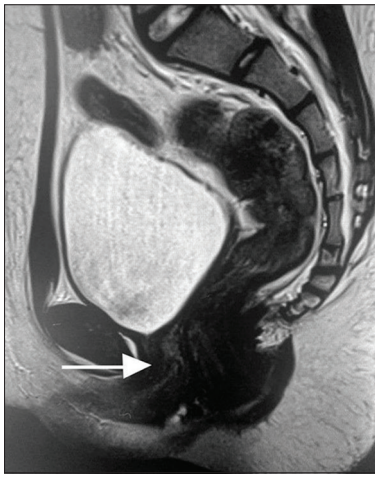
Sagittal T2-weighted imaging showing agenesis of the uterus and upper vagina
